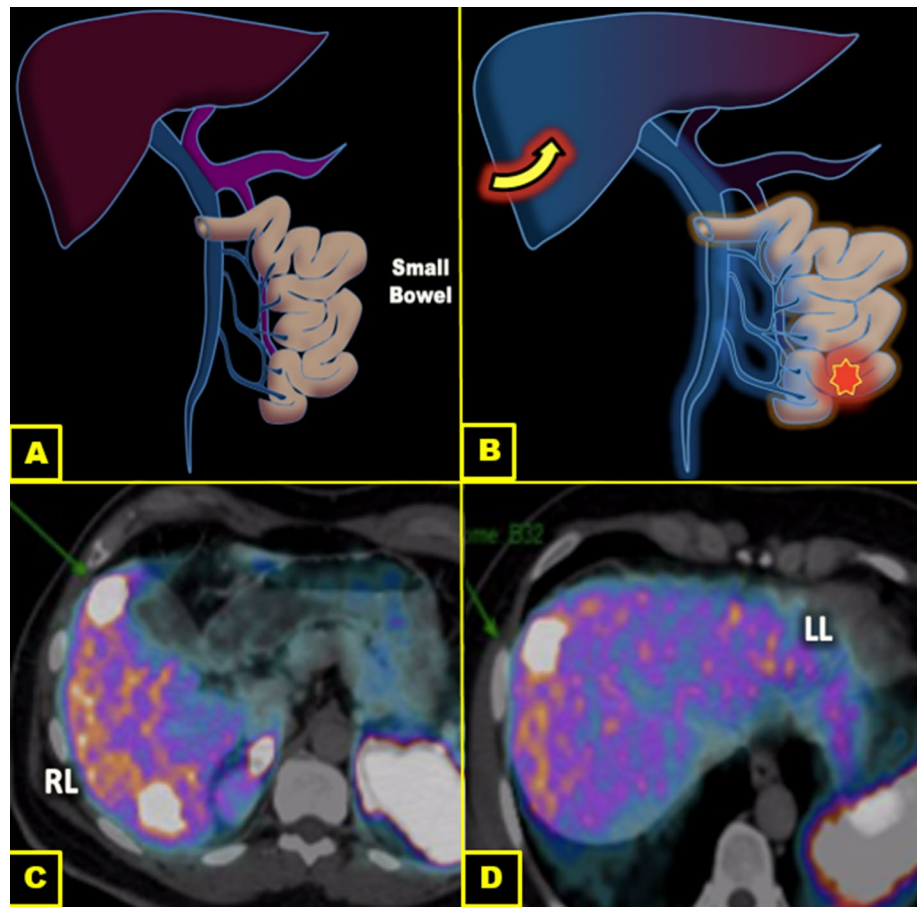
Small bowel drains to SMV (a), and tumors at this site may predominantly send metastases to the right hepatic lobe (b). PET/CT (with ^{68}Ga DOTATATE) from a patient with neuroendocrine tumor of the terminal ileus showing uptake lesions in the right hepatic lobe (c, d)
